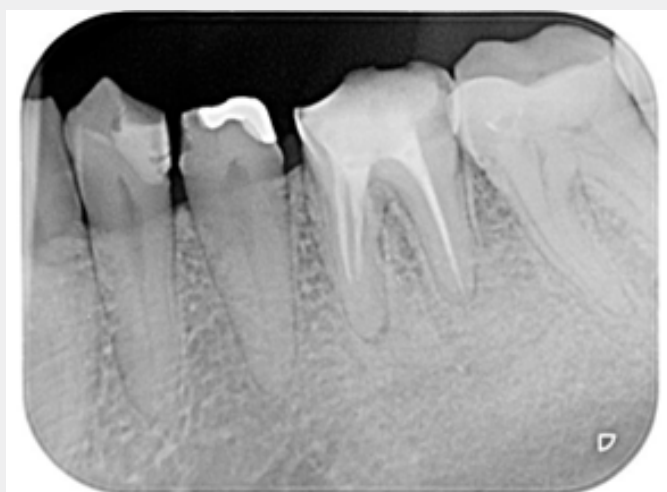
Radiographic changes during healing of chronic apical periodontitis after root canal filling.
